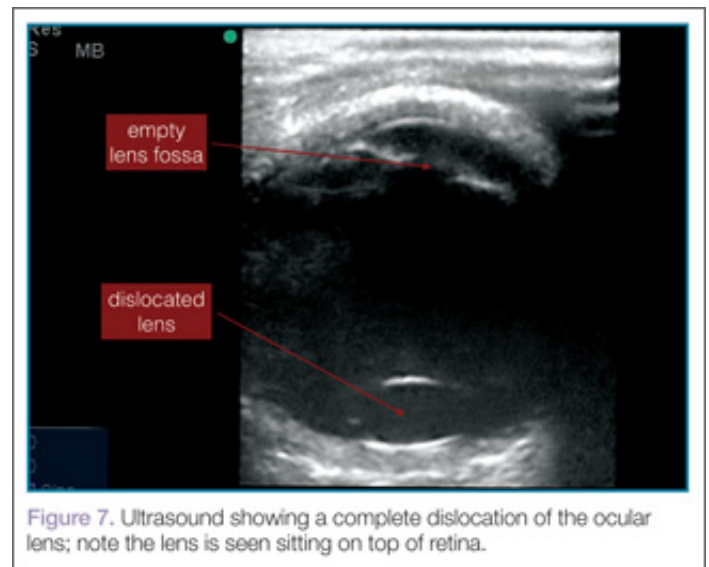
Ultrasound showing a complete dislocation of the ocular lens; note the lens is seen sitting on top of retina.
